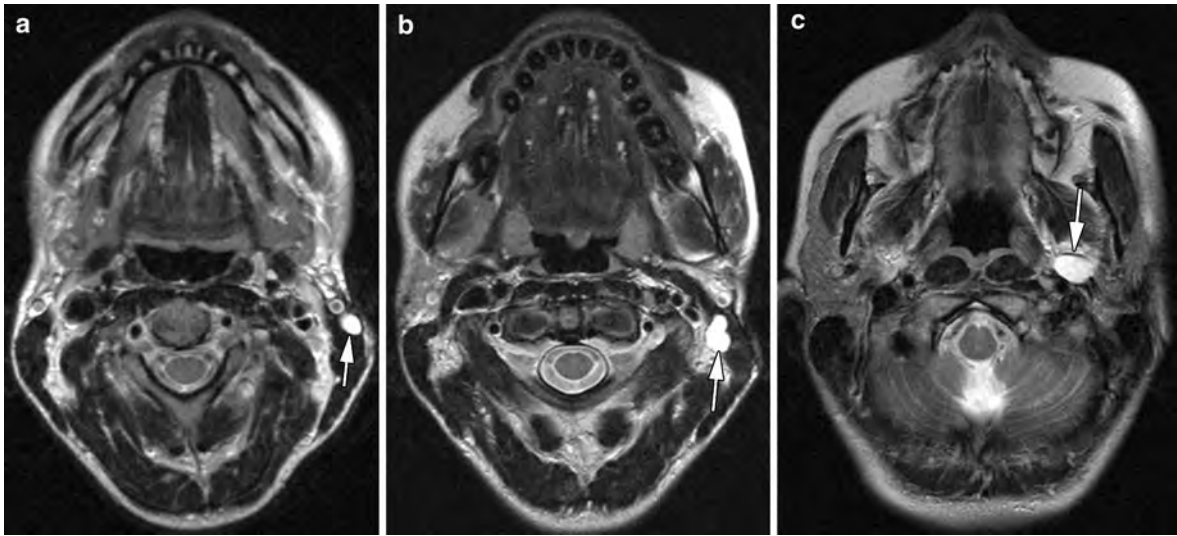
Axial T2-weighted spin echo images (a–c) in a patient presenting with an infra-auricular swelling, 9 years after surgery for pleomorphic adenoma. Several bright nodular lesions (arrows) are seen, superficial and deep to the sternocleidomastoid
